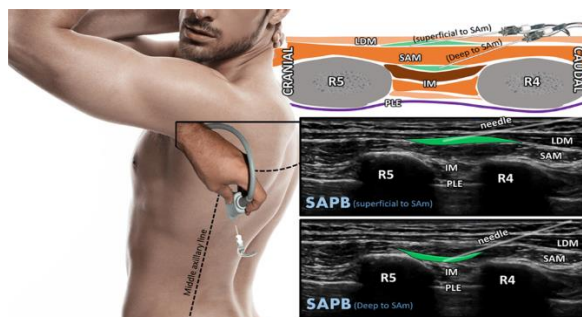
Ultrasound picture of the Serratus Anterior Block technique which was used in this study to administer the drug15
